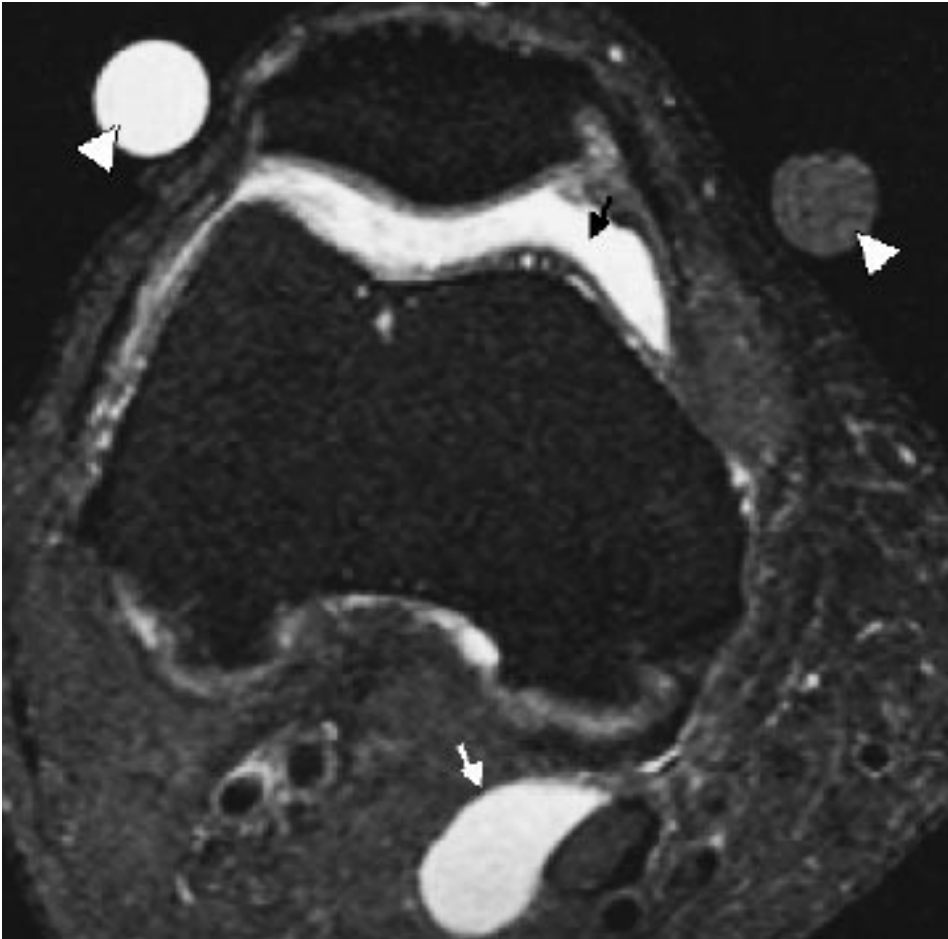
Transverse T2-weighted (2500/40) MR image shows a moderate joint effusion (black arrow) associated with pain and stiffness of the knee. Please note the presence of a Baker's cyst (white arrow) and the presence of an external marker (white arrowhead).
